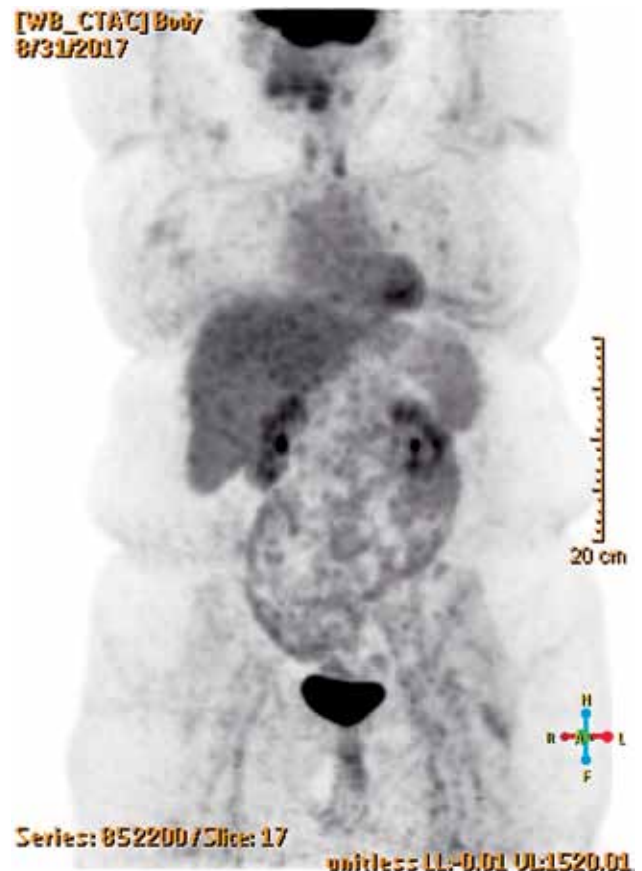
PET-CT scan four months after presentation shows no abnormal FDG activity in the lungs or elsewhere.
